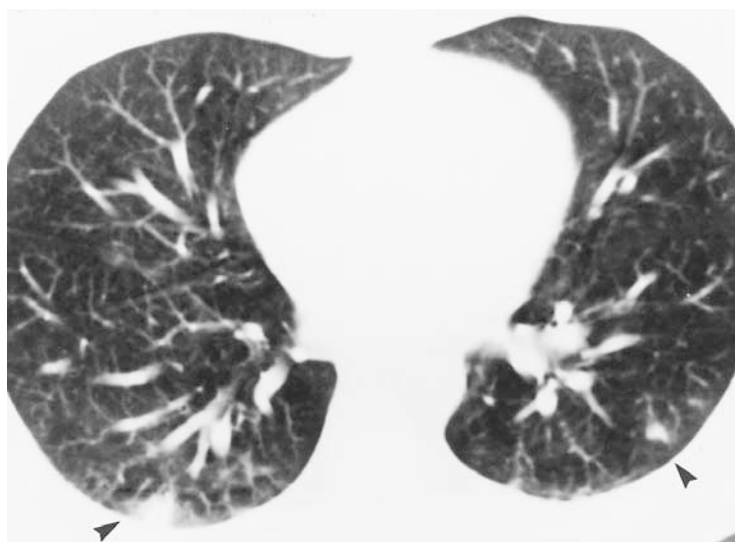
(16) Bleomycin-induced pulmonary toxicity in a 63-year-old man with nonseminomatous germ cell malignancy, nonproductive cough, dyspnea, and decreased  $D_LCO$ . (a) Chest CT scan demonstrates subtle, subpleural areas of ground-glass and linear opacity (arrows), particularly in the posterior lung bases. (b) Follow-up chest CT scan obtained 3 months later shows increasing subpleural areas of reticular and ground-glass opacity, findings compatible with progressive fibrosis. Diagnosis of drug toxicity was based on clinical findings and the temporal relationship to bleomycin therapy. (17) Bleomycin-induced pulmonary toxicity in a 35-year-old man with nonseminomatous germ cell malignancy, cough, dyspnea, and decreased  $D_LCO$ . Chest CT scan shows peripheral, poorly defined pulmonary nodules (arrowheads) that were not seen on prior CT scans. Transthoracic needle aspiration biopsy was negative for malignancy, and the nodules resolved after cessation of bleomycin therapy.
